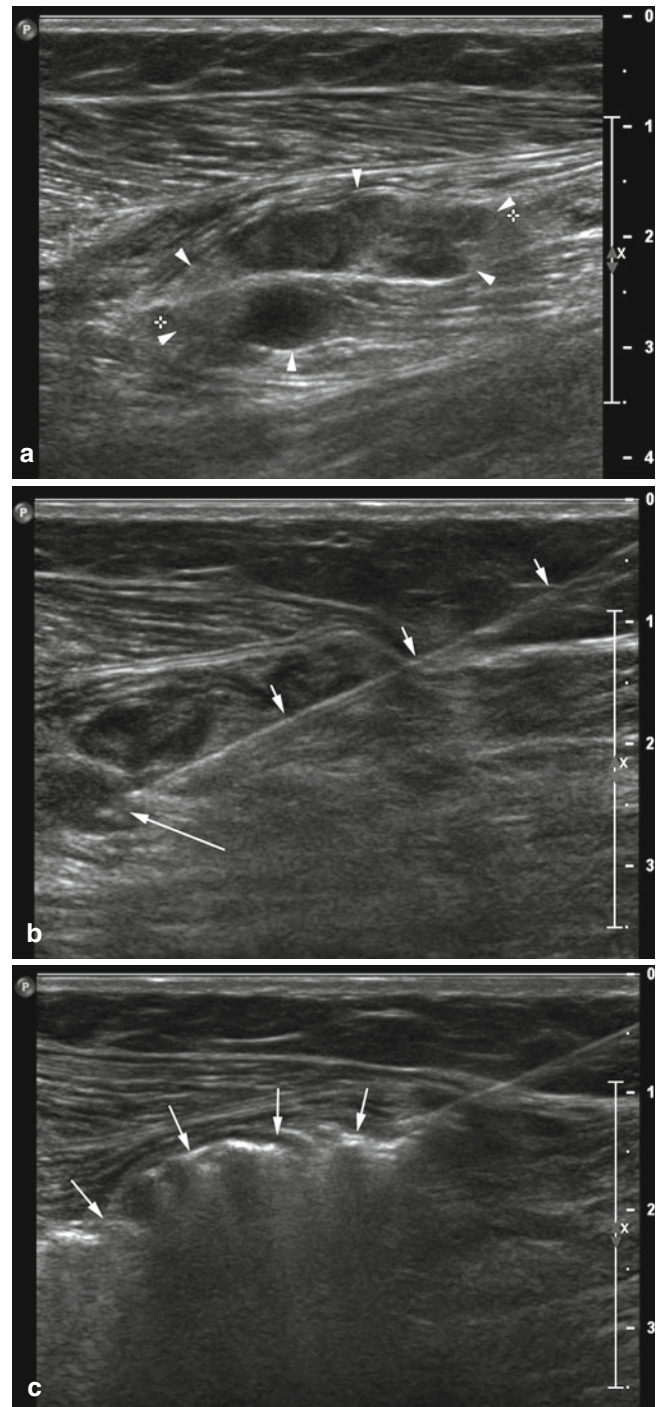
(a) Transverse grey scale image of a small intramuscular venous malformation (arrowheads) (same patient as in Fig. 7.6). (b) Direct puncture under sonographic control with a 21-gauge needle (arrowheads). The needle tip (arrow) is positioned inside the deepest lying cavern. (c) Homogeneous distribution of polidocanol foam inside the lesions (arrows)
